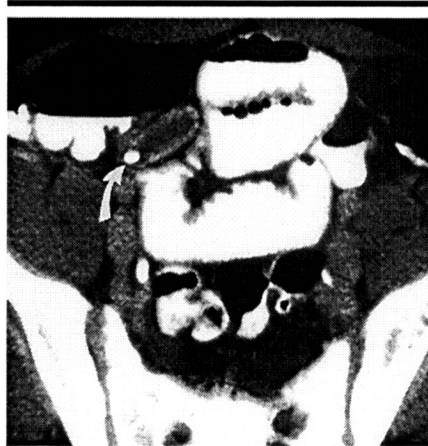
Enlarged appendix with an appendicolith. Transverse CT scan through the upper part of the pelvis after the administration of intravenous and rectal contrast material in a 15-year-old boy with acute right-lower-quadrant pain demonstrates an enlarged, fluid-filled appendix, which measures 8.5 mm in maximal diameter and contains an appendicolith (arrow).
